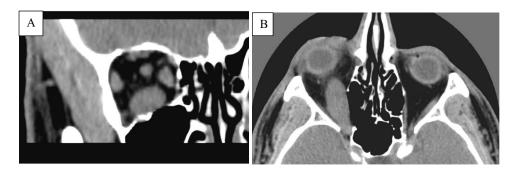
Coronal (A) and axial (B) CT slices shows massive enlargement of inferior rectus in right orbit.
